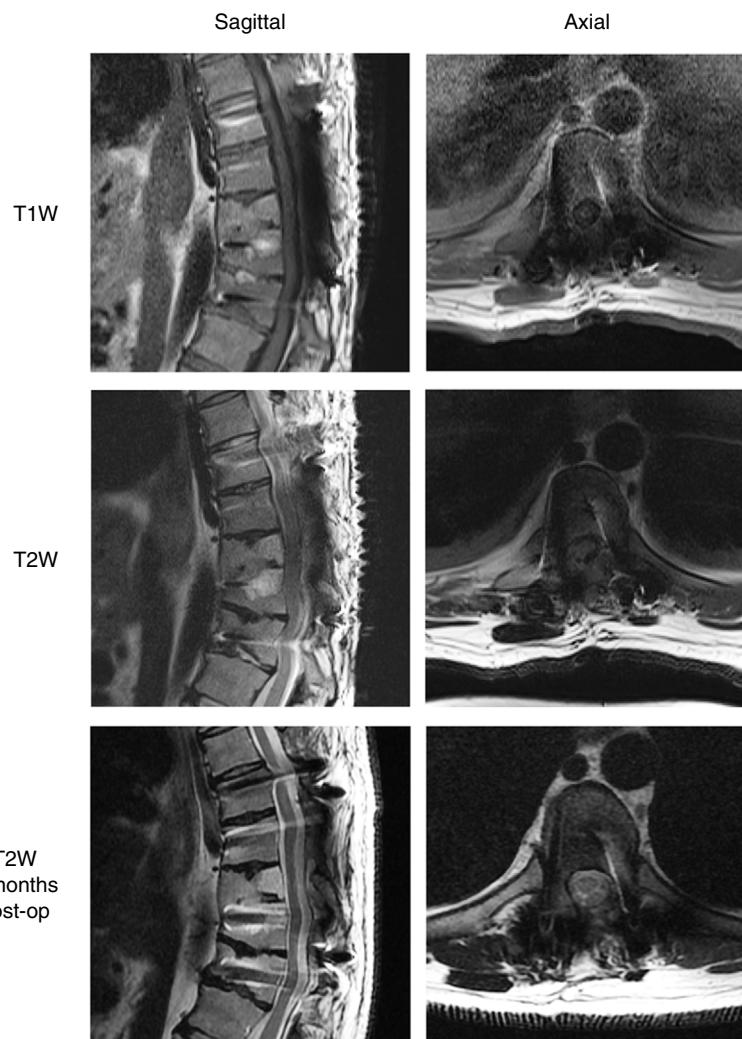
The patient underwent MRI on postoperative day 6, as well as a follow-up 6 months later, that demonstrated decompression of the spinal cord. All axial images were taken at the level of T8.
